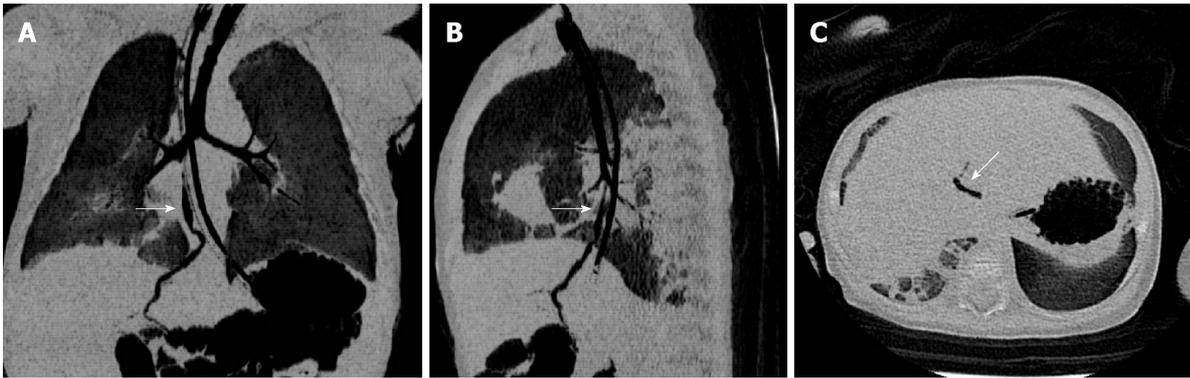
Computed tomography images. A and B: Computed tomography (CT) scan and tracheoesophageal reconstruction; the arrow indicates the abnormal connection between the right bronchus and biliary tract. C: CT scan; the white arrow indicates gas in the biliary tract.
